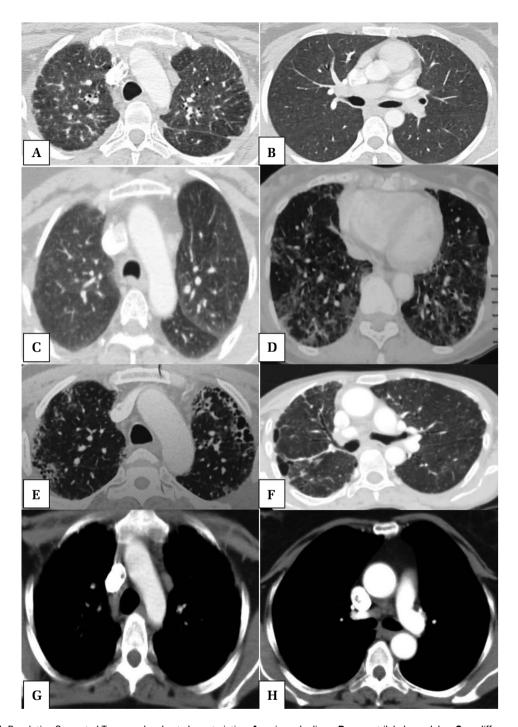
High-Resolution Computed Tomography chest characteristics; A — irregular lines; B — centrilobular nodules; C — diffuse ground glass; D — patchy ground glass; E — honeycombing; F — traction bronchiectasis; G — para-aortic mediastinal lymphadenopathy; H — pre-carinal mediastinal lymphadenopathy
